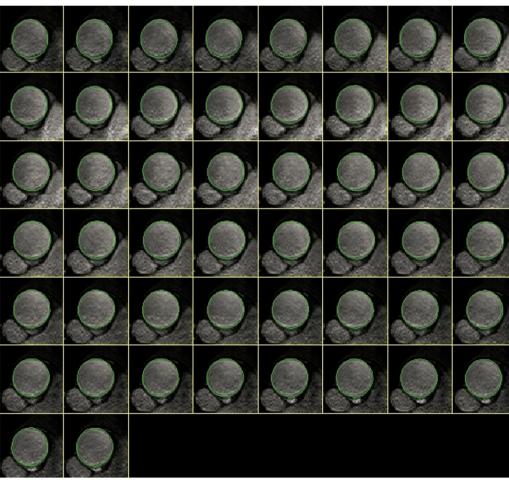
(a) Parasagittal (candy-cane) gradient-echo image depicting levels of aortic strain measurement: ascending and proximal descending aorta on the axial MR image at the level of the right pulmonary artery (white line) and the distal descending aorta at the level of the diaphragm (gray line). (b) Aortic lumen segmentation using AR-Terial-FUNction software on 50 frames throughout the cardiac cycle.
